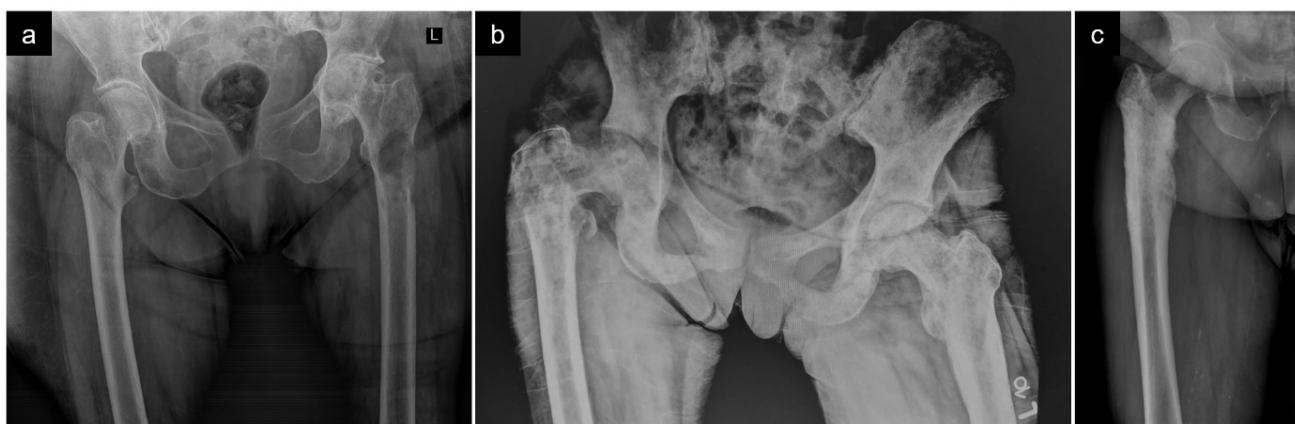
X-ray presentation of bone metastases: a) Lytic lesion in proximal femur – lung cancer SM; b) Mixed lesion with pathological fracture of trochanteric region – breast cancer SM; c) Blastic lesion involving trochanteric region and proximal diaphysis – prostate cancer SM
